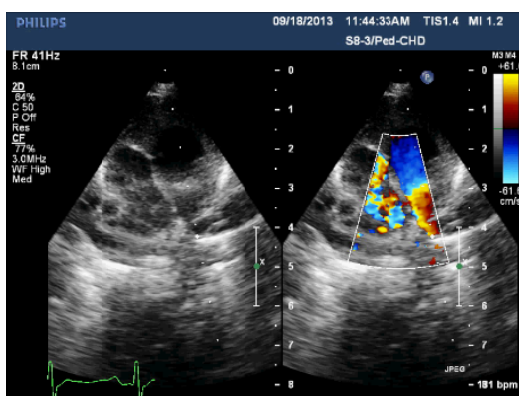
Colour Doppler image showing the origin of the RPA from aorta and MPA continuing as LPA.
